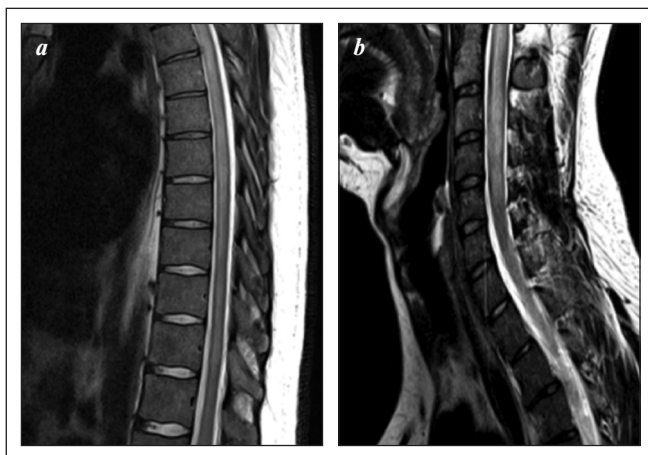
Spinal cord MRI, T2 weighted image (a, b): inflammatory changes at the level of C₇-T₈
